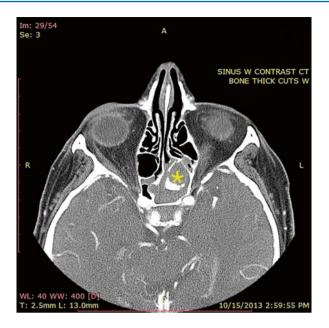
Sinus CT angiogram demonstrates hyperdensity within an opacified left sphenoid sinus. This appearance is consistent with isolated sphenoid fungus ball
